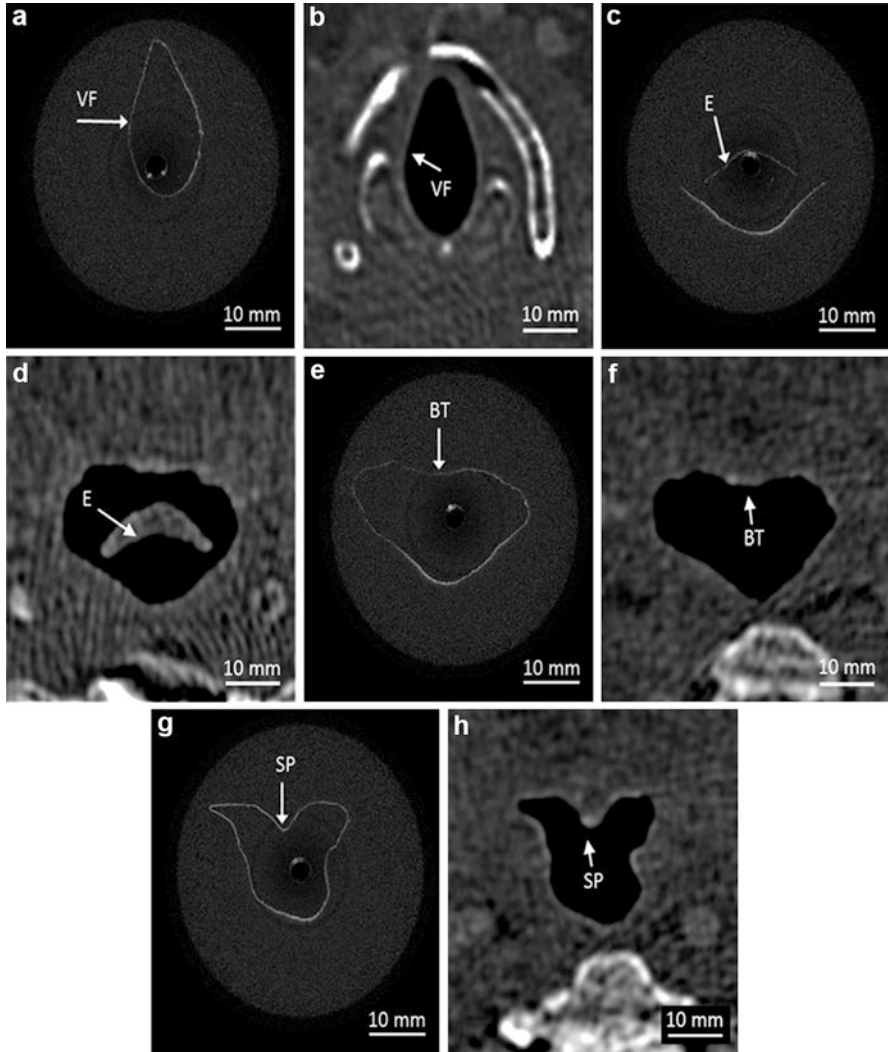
Comparison of OCT images (a, c, e, g) in model with normal CT scan (b, d, f, h). Vocal folds (VF), epiglottis (E), base of tongue (BT), and soft palate (SP)
